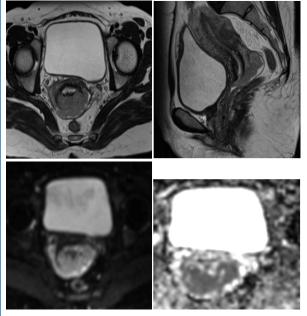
Hyperintense lesion in the cervix, with serosal infiltration of posterior urinary bladder wall in T2WI showing restricted diffusion in corresponding DWI and ADC images.
